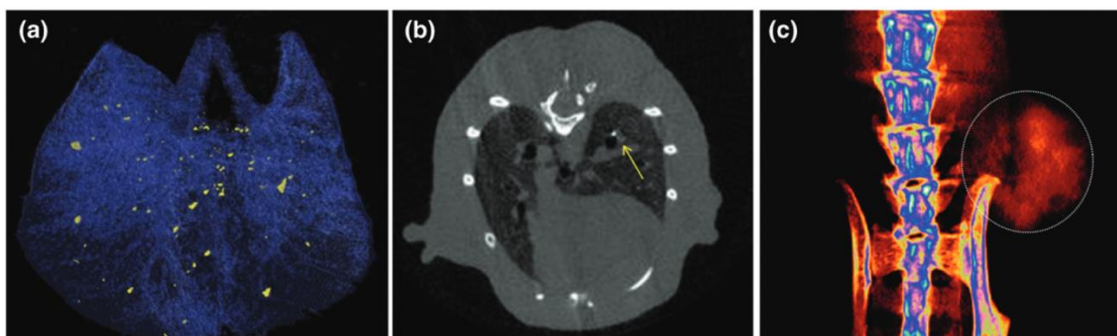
CT scans demonstrated AuNPs migration (a) 3D CT image of AuNPs accumulation in the lungs (b) 2D CT image of AuNPs in lung (c) Accumulation of AuNPs in tumor (135).
